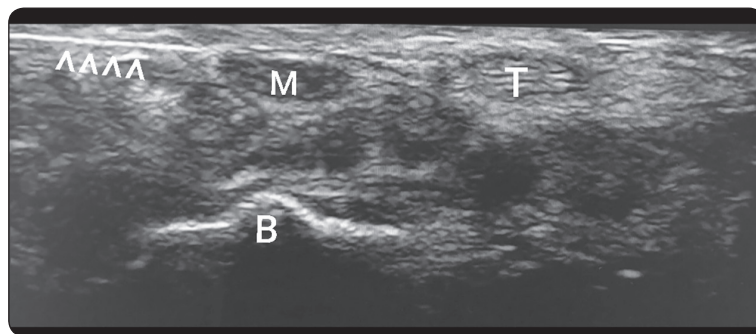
Ultrasonographic view of perineural injection around the median nerve using the short-axis, ulnar approach, and in-plane method by preserving neurovascular structures after the median nerve was located. M: Median nerve; B: Bone; T: Tendon; Short arrowheads: Needle
